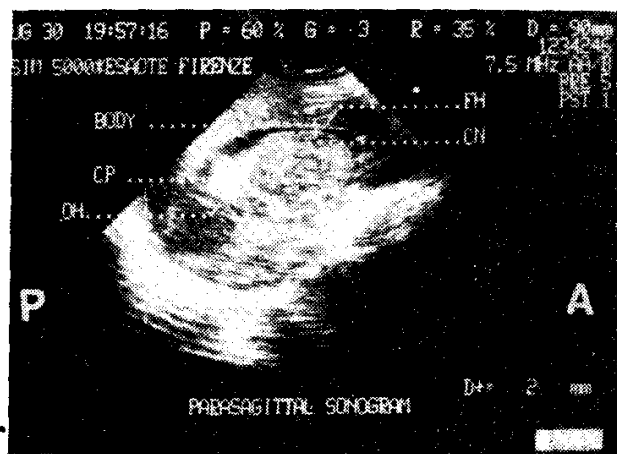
Para-sagittal sonogram showing normally echo-free lateral ventricle (frontal horn, FH; body; occipital horn, OH), echo-dense choroid-plexus (CP) and hypoechoic thalamus (TH).
